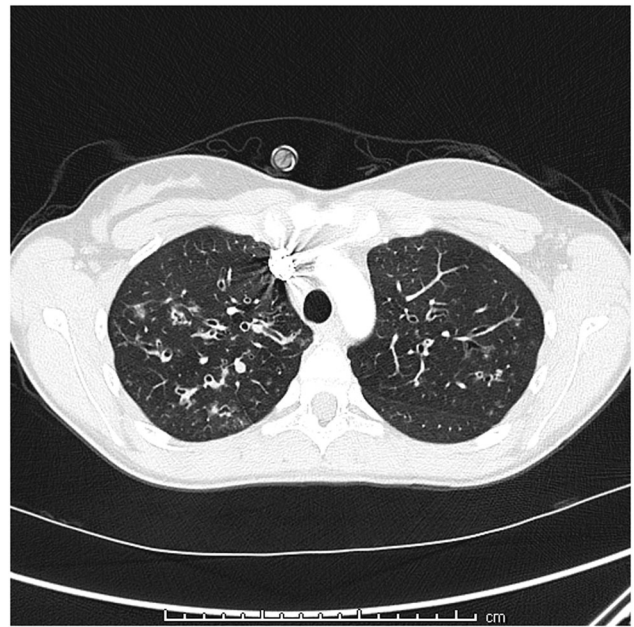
Case 9, chest CT: apical predominant bronchiectasis with bronchial wall thickening; tree-in-bud nodularity with pulmonary nodules, some with cavitation. CT, computed tomography
